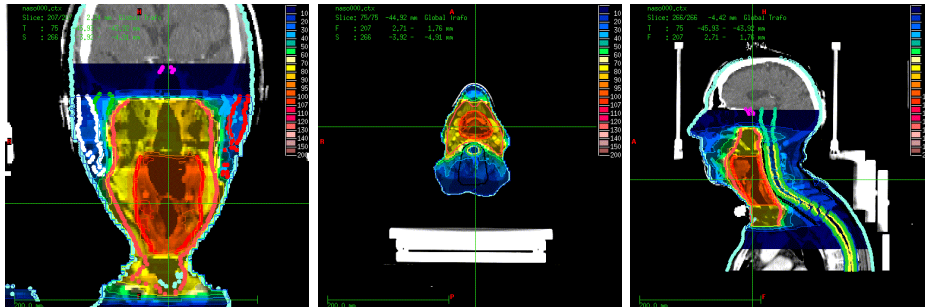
CT image of the head-and-neck case, overlaid with the dose distribution from optimisation using the 0 T beamlet.
